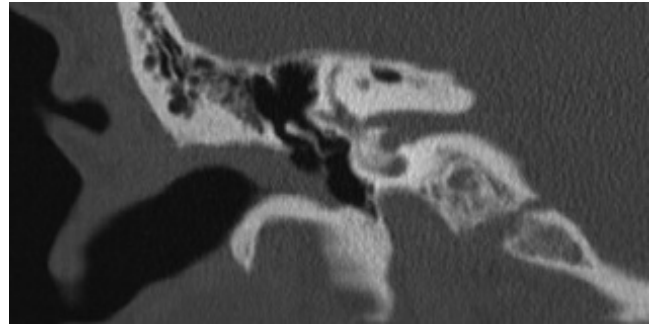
Coronal CT of right external ear canal showing medial atresia.
